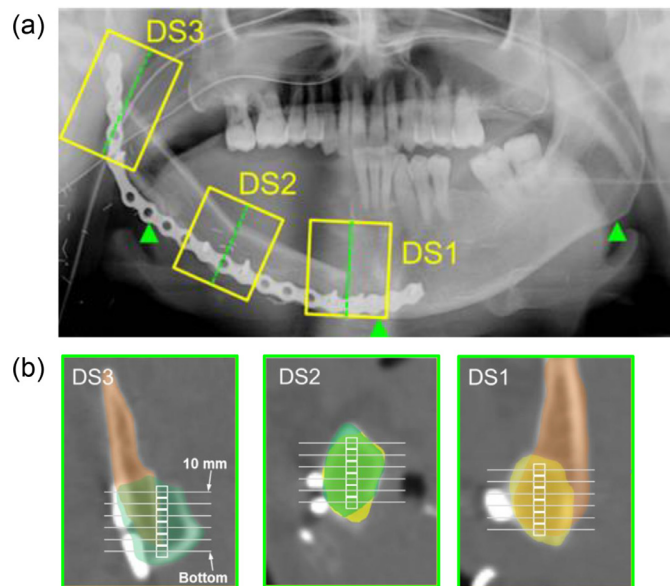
Clinical X-ray and CT images for assessment.
